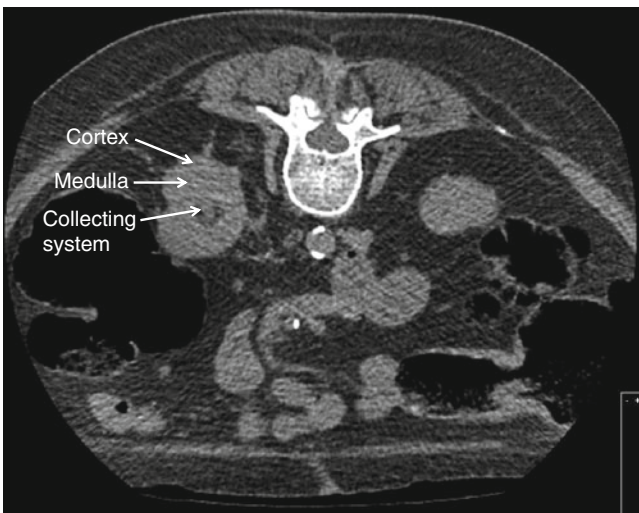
Prone unenhanced CT at the level of the lower pole of the left kidney
